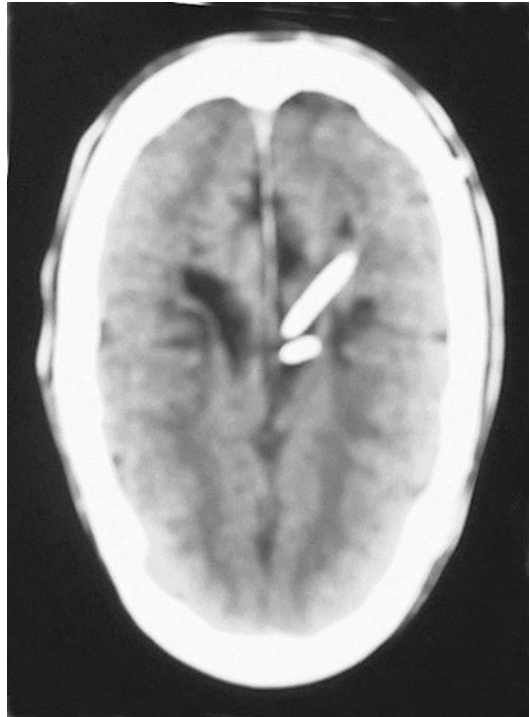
CT scan of the head of a patient after ventriculoperitoneal shunt
